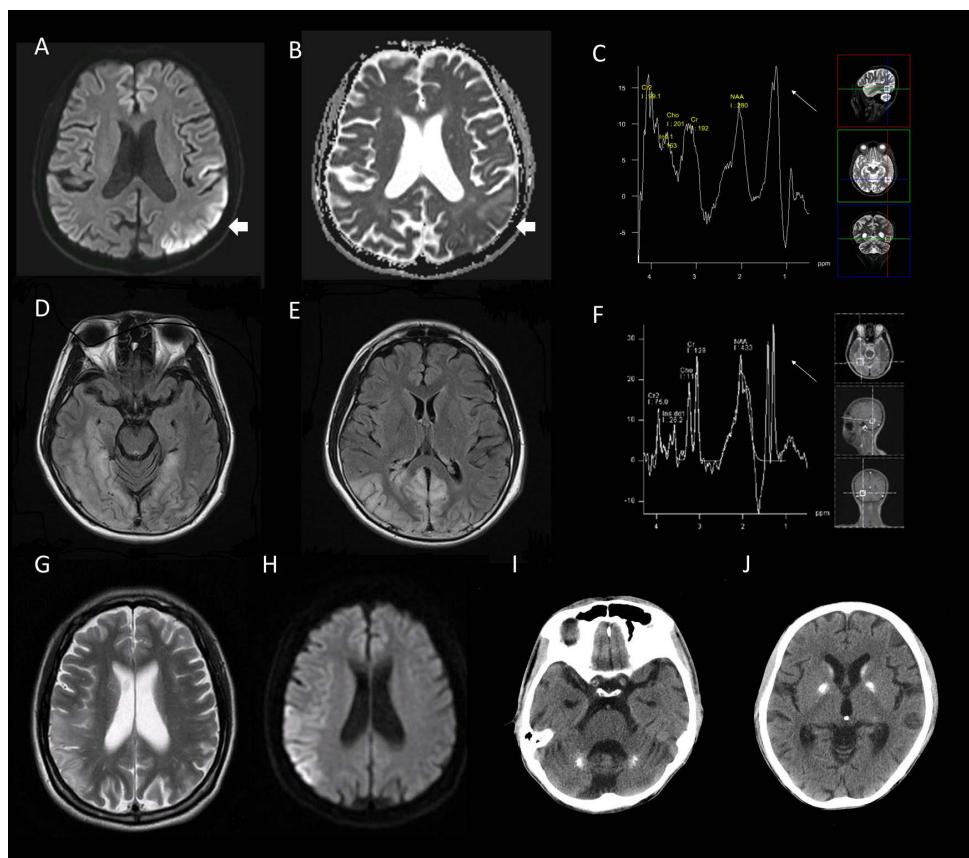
MRI of Mr A (case 1, A-C) showed restricted diffusion over left parietal and occipital cortex (arrow, A), without significant reduction of ADC map (arrow, B); MRS revealed a high lactate double peak at 1.33 ppm (small arrow, C). MRI FLAIR of Mr C (case 3, D-F) showed gyral edema over bilateral occipital and temporal region, the edema was restricted to subcortical white matter (D & E). MRS showed a high lactate double peak at 1.33 ppm (small arrow, F). G & H: MRI of Miss E (case 5) during her second stroke-like episode showed hyperintense T2 lesion at right parietal cortex (G) with restricted diffusion (H). I & J: Brain CT of Mr G (case 7) found cerebral and cerebellar atrophy with bilateral basal ganglia calcifications.
